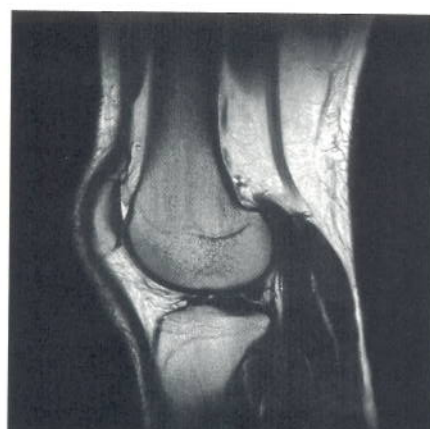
Turbo Spin Echo T2-weighted, 1024 matrix.
